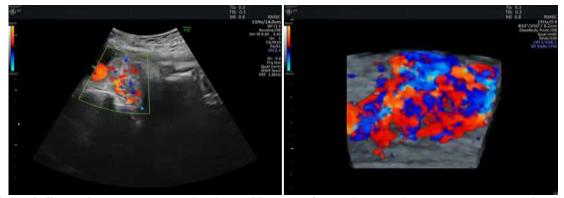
SRI II 4 Ultrasound examination at 29 weeks of gestation showing the tumor vascularization. Figure 4. Prenatal images of Color Doppler ultrasonography at 29 weeks of gestation showing the tumor formation and blood flow in the tumor.
